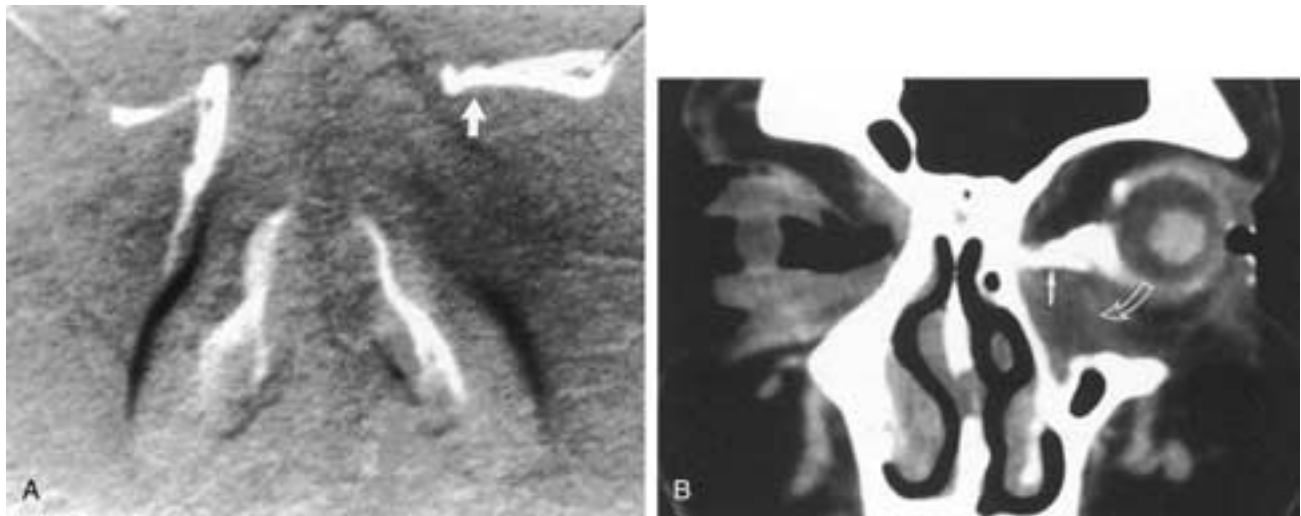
CT-DCG of mass lesions: inner canthus. CT-DCG allows better assessment of the extent of adjacent tissue involvement than DCG alone and better assessment of NLDS involvement than CT alone. A to C, Patient presents with left inner canthus prominence and epiphora. A, DCG shows superior displacement of the left canaliculi (arrow) with no visualization of the left lacrimal sac or nasolacrimal duct. B, Coronal CT-DCG shows displacement of the proximal NLDS (solid arrow) by a soft-tissue mass in the inner canthus (open arrow).
